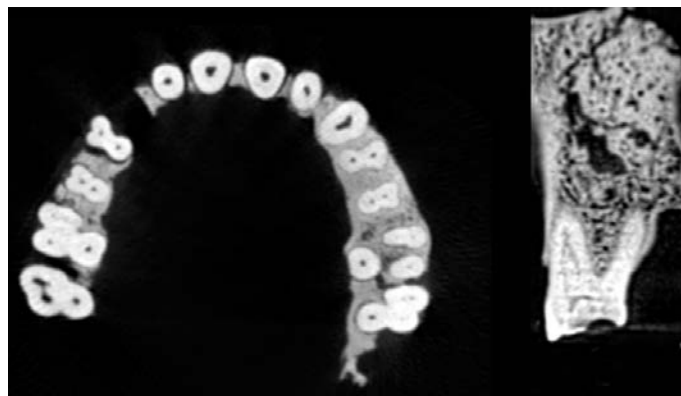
Cbct image of the maxillary first molar mesial canal with two canals.
